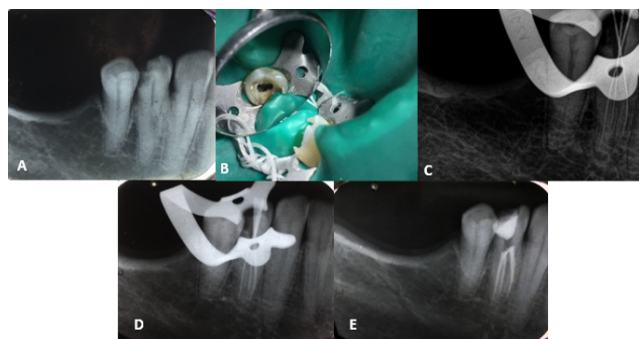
Mandibular right first premolar (#44) A. Preoperative radiograph, B. Access cavity with three canals, C. Working length radiograph, D. Master cone radiograph and E. Postobturation radiograph.
